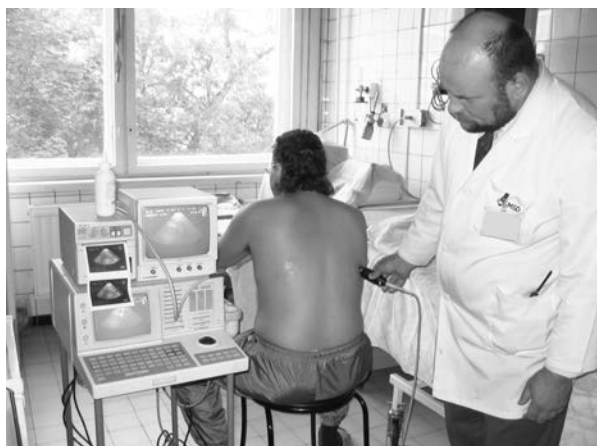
Location of the pleural fluid by ultrasound method.
